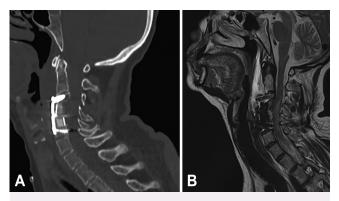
A: Postoperative cervical CT scan obtained immediately after the first surgical attempt. The sagittal scan with "bone window" shows appropriate anterior instrumentation of the cervical spine with the correction of listhesis and no worsening of preoperative stenosis. B: Postoperative sagittal T2-weighted MR image of the cervical spine, showing marked cervical lordosis with visible degenerative changes of the spondylosis deformans and discrete spondylarthrosis on the right. Worsening myelopathy was also noted.
